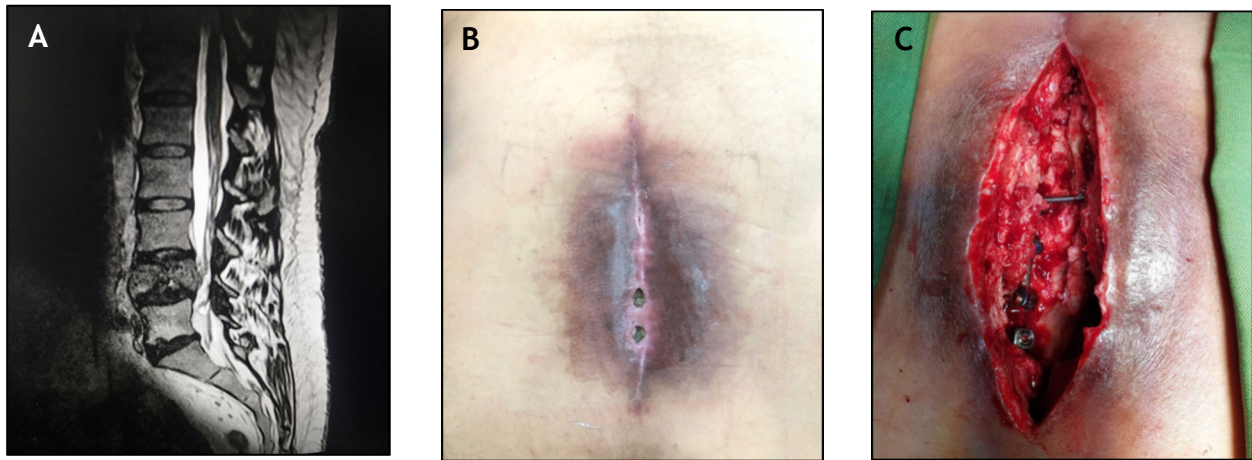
Magnetic resonance imaging of the lumbar spine showing a mass-like lesion within the L4 vertebral body [pointed by an arrow] (A); image of the infected wound on admission (B); intraoperative image of debridement and wound exploration (C)
